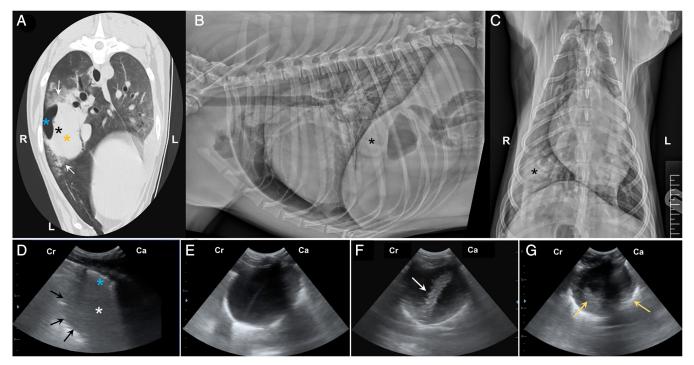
Transverse CT lung window at the level of intercostal space 7 (A), left lateral and dorsoventral radiographs (B and C), transcostal sonograms at the level of the 7th intercostal space on day 1 (D), 4 (E), 7 (F) and 16 (G). The CT image was acquired with the patient in left lateral recumbency but for ease of viewing has been rotated 90° . TPP (black asterisk), with haemorrhage (yellow asterisk) and gas (blue asterisk). Multifocal regions of ground glass opacity to consolidation were suspected to be contusions (white arrows). Radiographs highlight the TPP as a round soft tissue opacity in the right caudoventral lung (black asterisk). POCUS on day 1 revealed a hypoechoic pulmonary mass (black arrows) containing a bright interface (blue asterisk) with dirty acoustic shadowing (white asterisk) consistent with intralesional gas. The gas cap had resolved by day 4. There is a gradual increase in the echogenicity of the material within the TPP consistent with thickening of fibrous strands (white arrow) and peripheral organisation of the haematoma (yellow arrow) (E-G)
